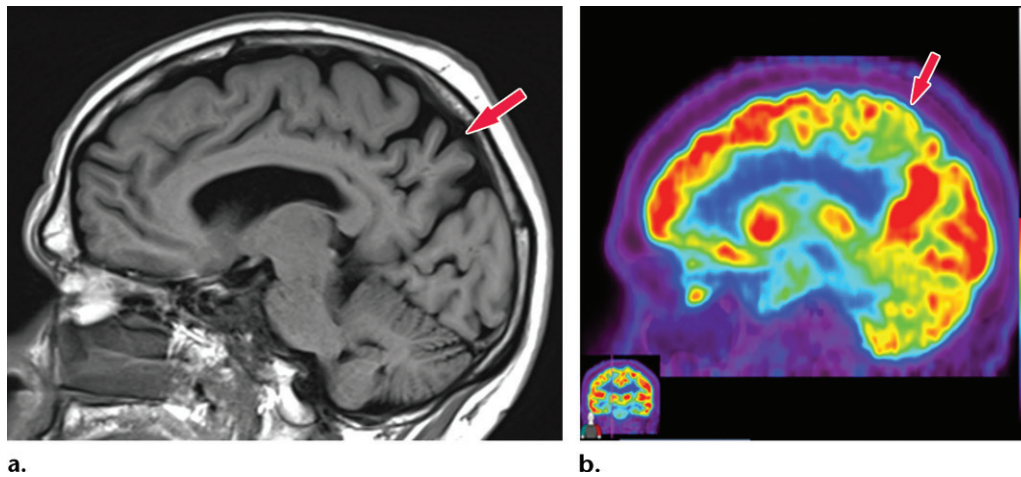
Alzheimer disease. (a) Sagittal T1-weighted MR image in a patient with memory loss shows disproportionate moderate volume loss in the precuneus (arrow), a finding suspicious for Alzheimer disease. The remainder of the brain parenchymal volume is relatively preserved. (b) Sagittal ¹⁸F-FDG PET image shows corresponding decreased activity in the precuneus (arrow). Image inset shows a coronal section through the middle of the brain in this particular case to aid in lateralization. Normal uptake is depicted in the frontal and occipital regions, reinforcing the diagnosis of Alzheimer disease.
